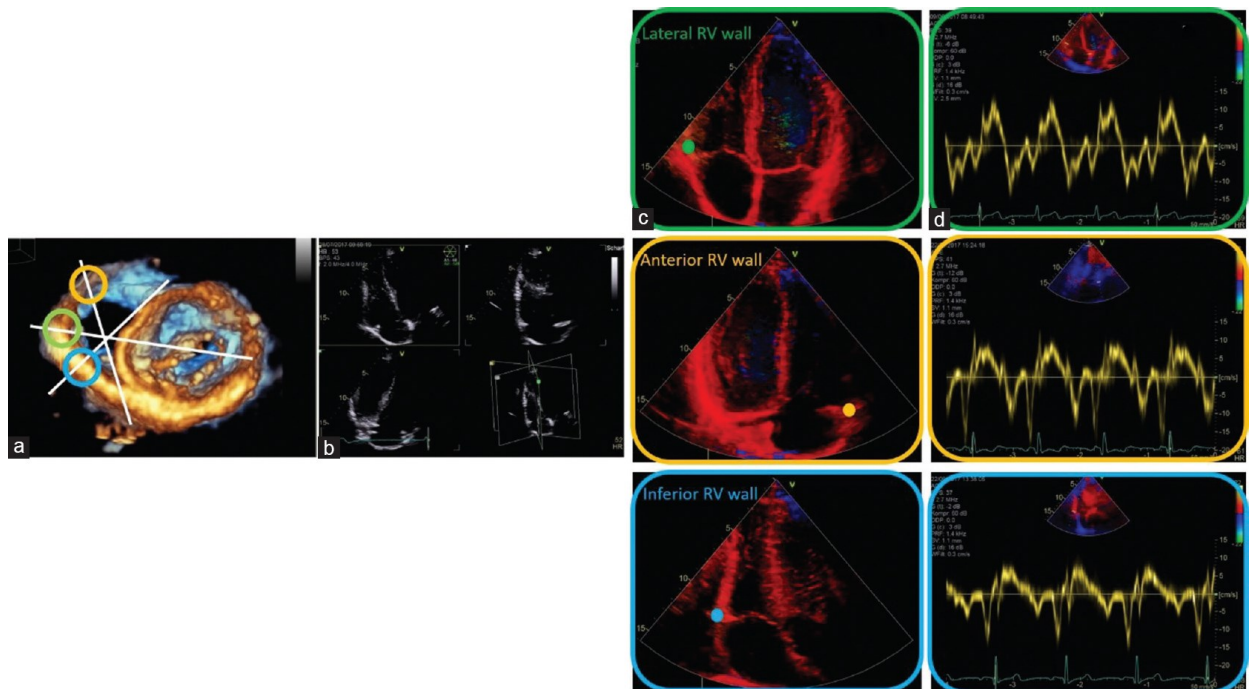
Transthoracic three-dimensional echocardiography, documenting the en-face short-axis view to the mitral valve from the LV cavity, is used only for demonstrative purposes. In white, the cutting planes of RV are labeled. The green circle indicates the lateral RV wall, the yellow circle the anterior RV wall, and the blue circle the inferior RV wall (a). Triplane imaging of the RV was obtained, focusing on RV using the apical four-chamber view as the primary scan plane (b). Complementary views of RV using TDI in addition to the conventional standardized RV views were recorded (c). The sample volume of pulsed-wave TDI was placed on the RV lateral, anterior, and inferior wall at the lateral, anterior, and inferior tricuspid annulus (in green, yellow, and blue, respectively). Tissue velocities were obtained from the three RV walls, respectively (d). LV = Left ventricular, RV = Right ventricle, TDI = Tissue Doppler imaging
